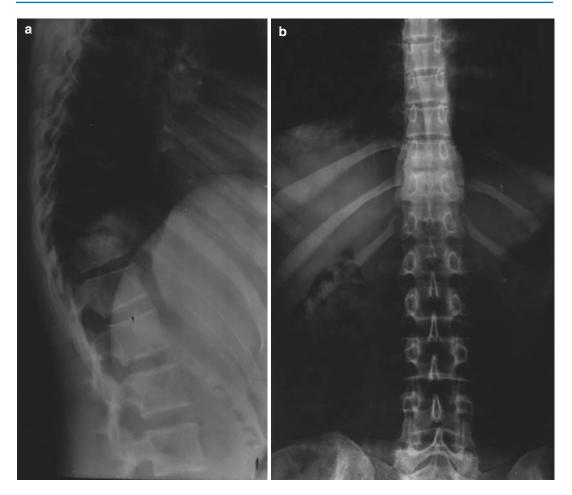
Preoperative radiographs lateral (\mathbf{a}) and anteroposterior (\mathbf{b}) are essential in preoperative planning as these can depict any deviation in the curvature of the spine and configuration of the vertebral bodies
